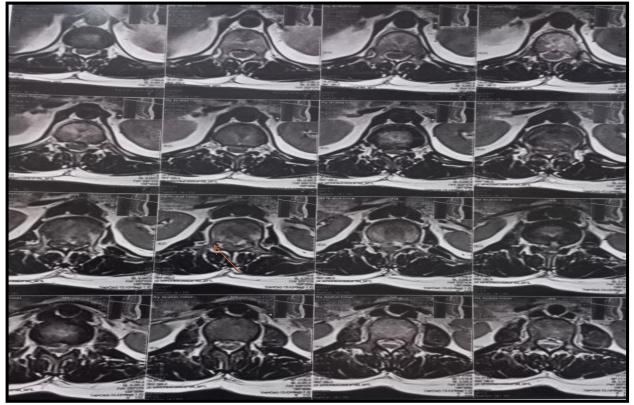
Preoperative MRI L.S , reveal compressed fracture L1, reveal retropulsed bone fragment with compression to conus medullaris.
